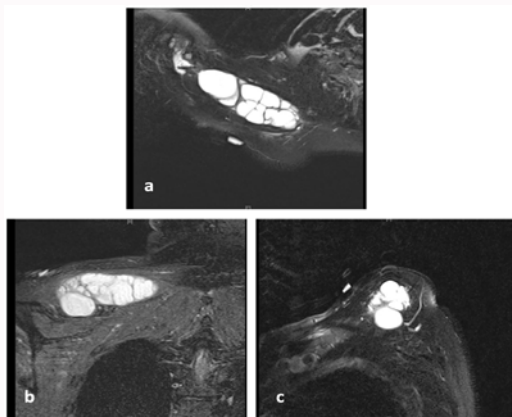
Axial, coronal, and sagittal MRI images of the chest without contrast, respectively. Shows large, loculated, T2-enhancing mass over the right posterior shoulder region.
